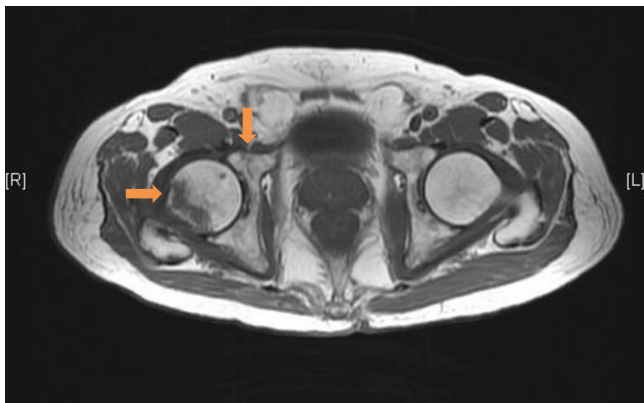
MRI scan of the pelvis of Patient 3, showing a non-displaced fracture of the anterior column of the right acetabulum. There is also a right non-displaced sub-capital neck of femur fracture with surrounding bone and soft tissue oedema.
